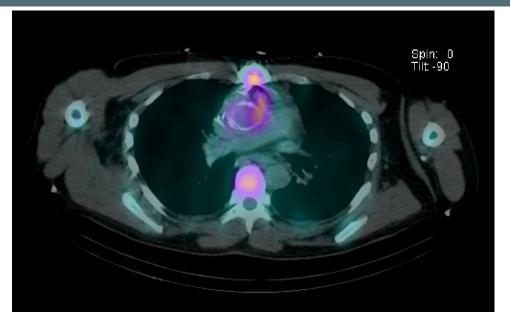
Tc-99m HMPAO labelled WBC scintigraphy showing "lowgrade inflammation/infection at the base of the aortic root graft extending into the mediastinum". baseline functional.
